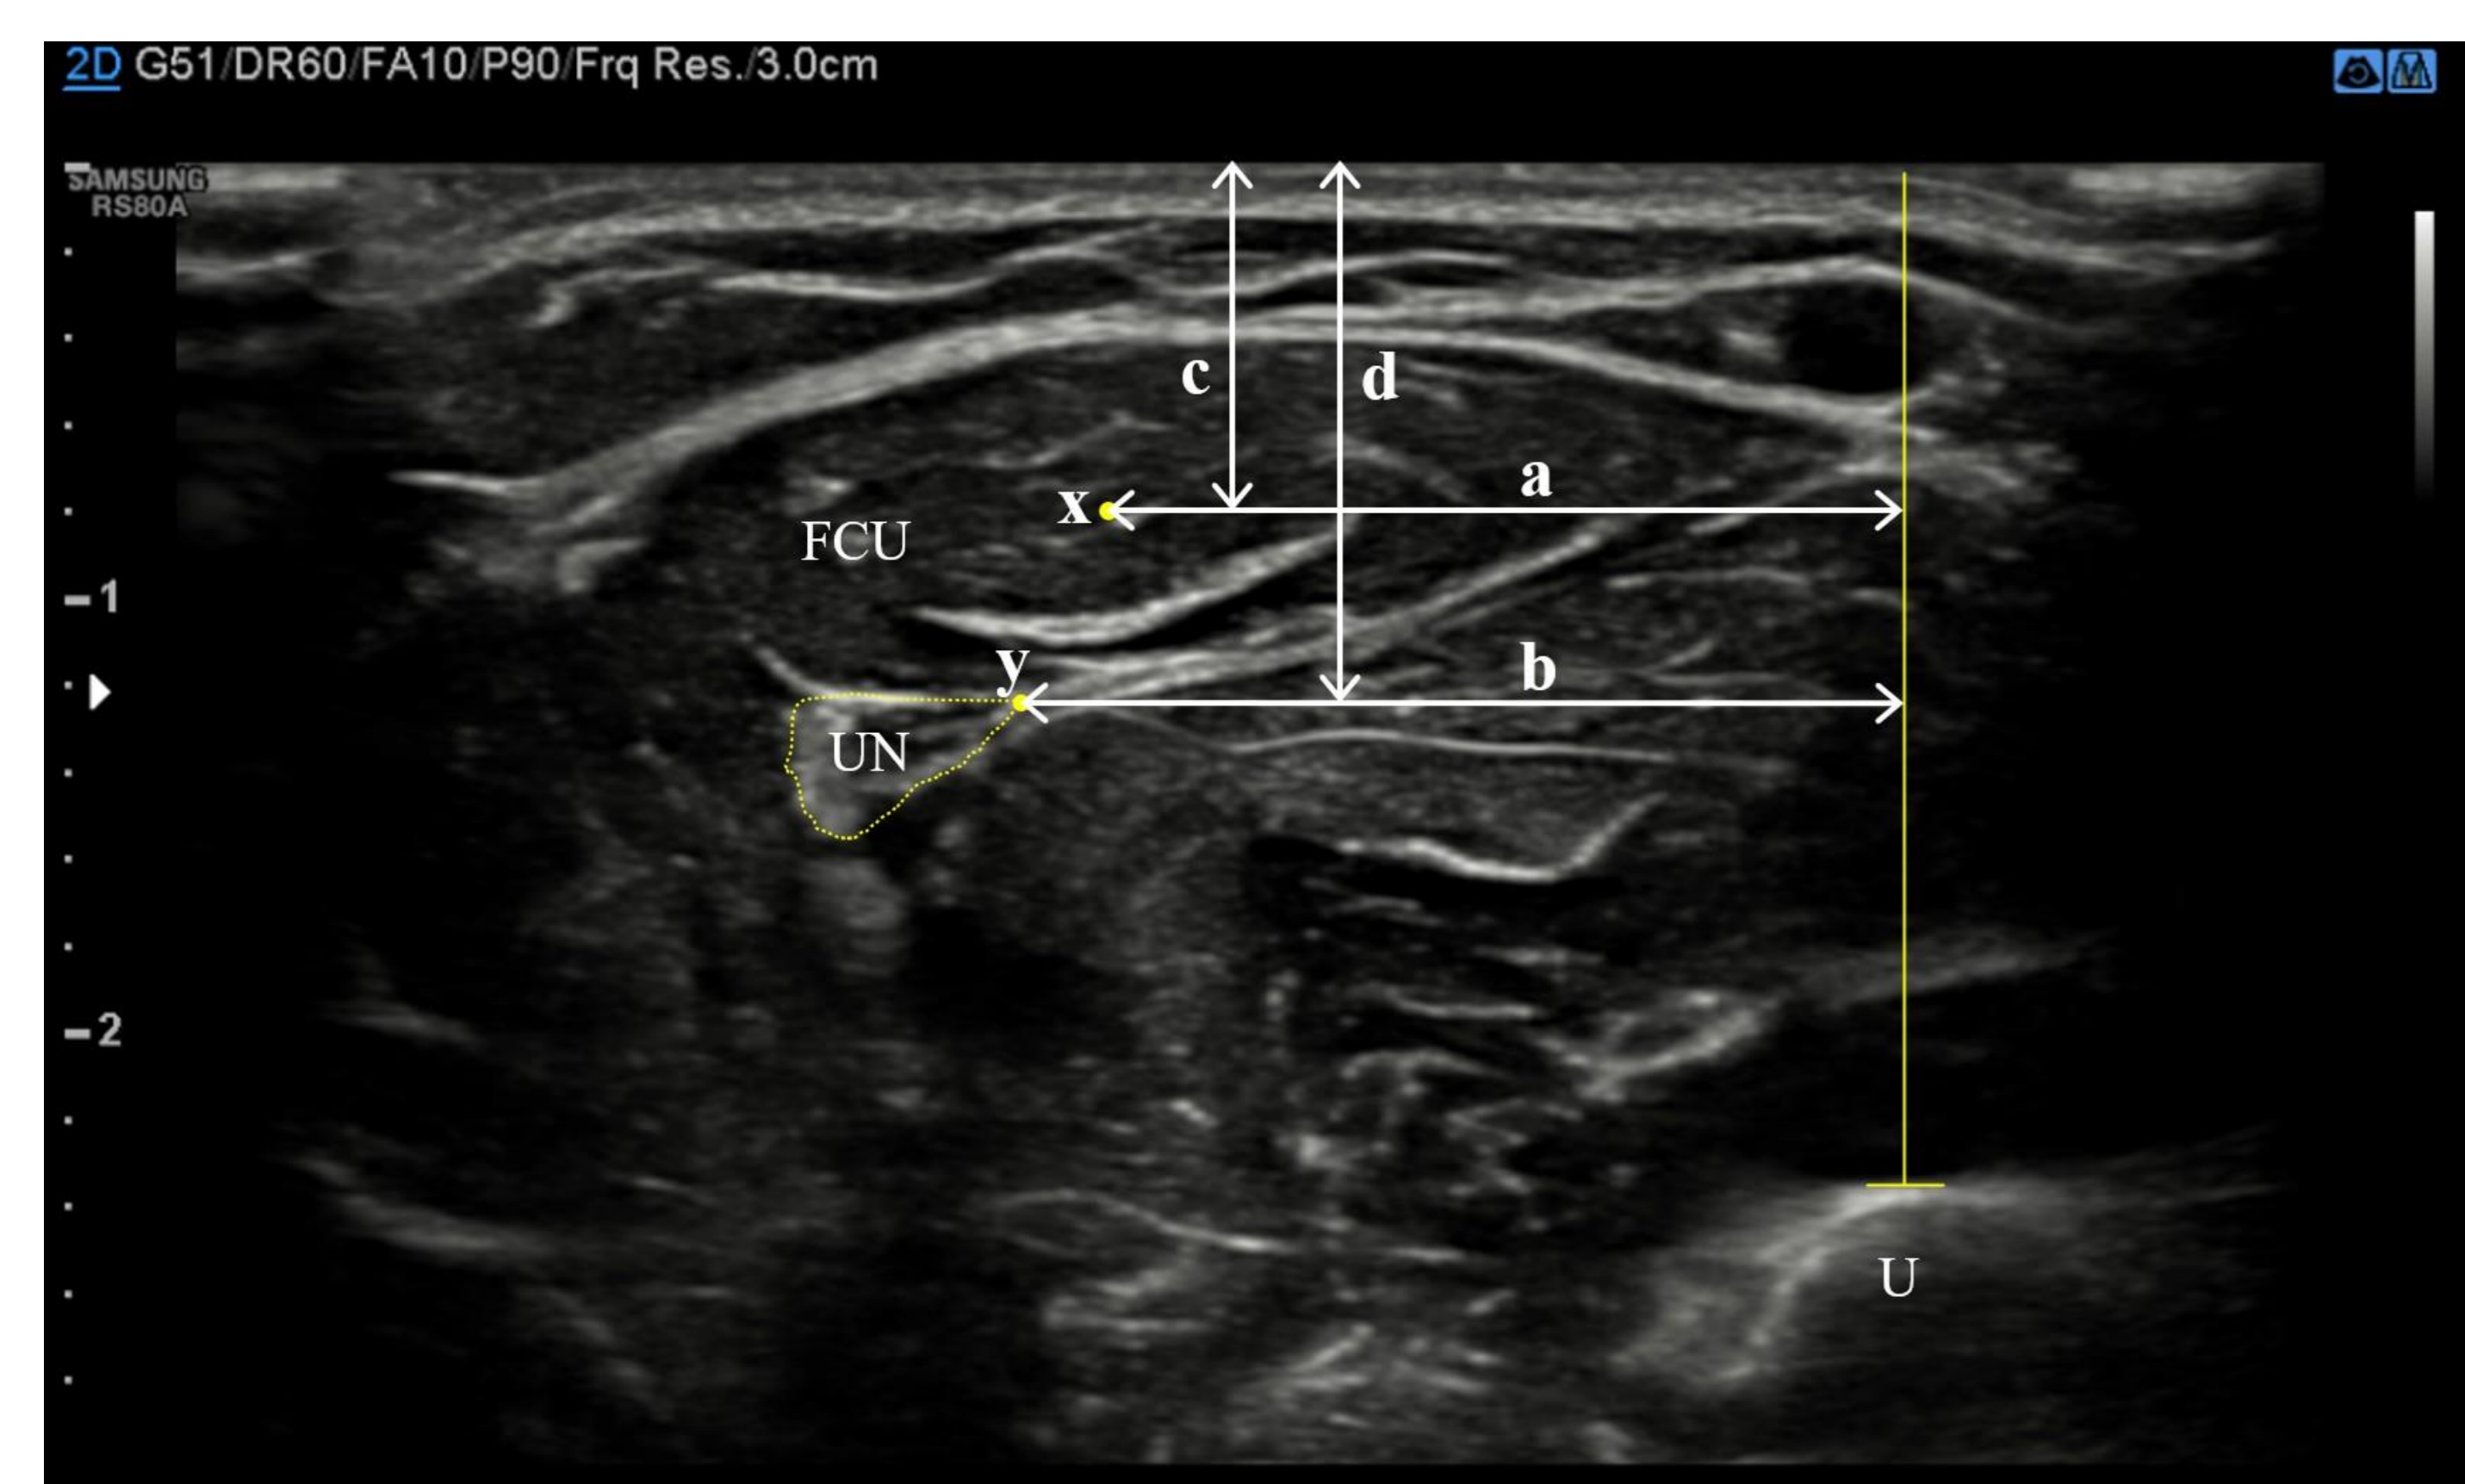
Ultrasonographic measurements of FCU and surrounding structures.
